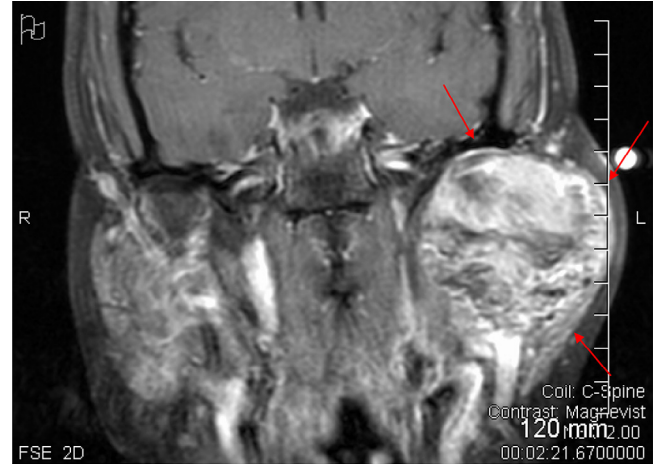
Contrast-enhanced coronal computed tomography shows a solid enhancing mass in the left masticator space surrounding the mandible and displacing the parapharyngeal space.
